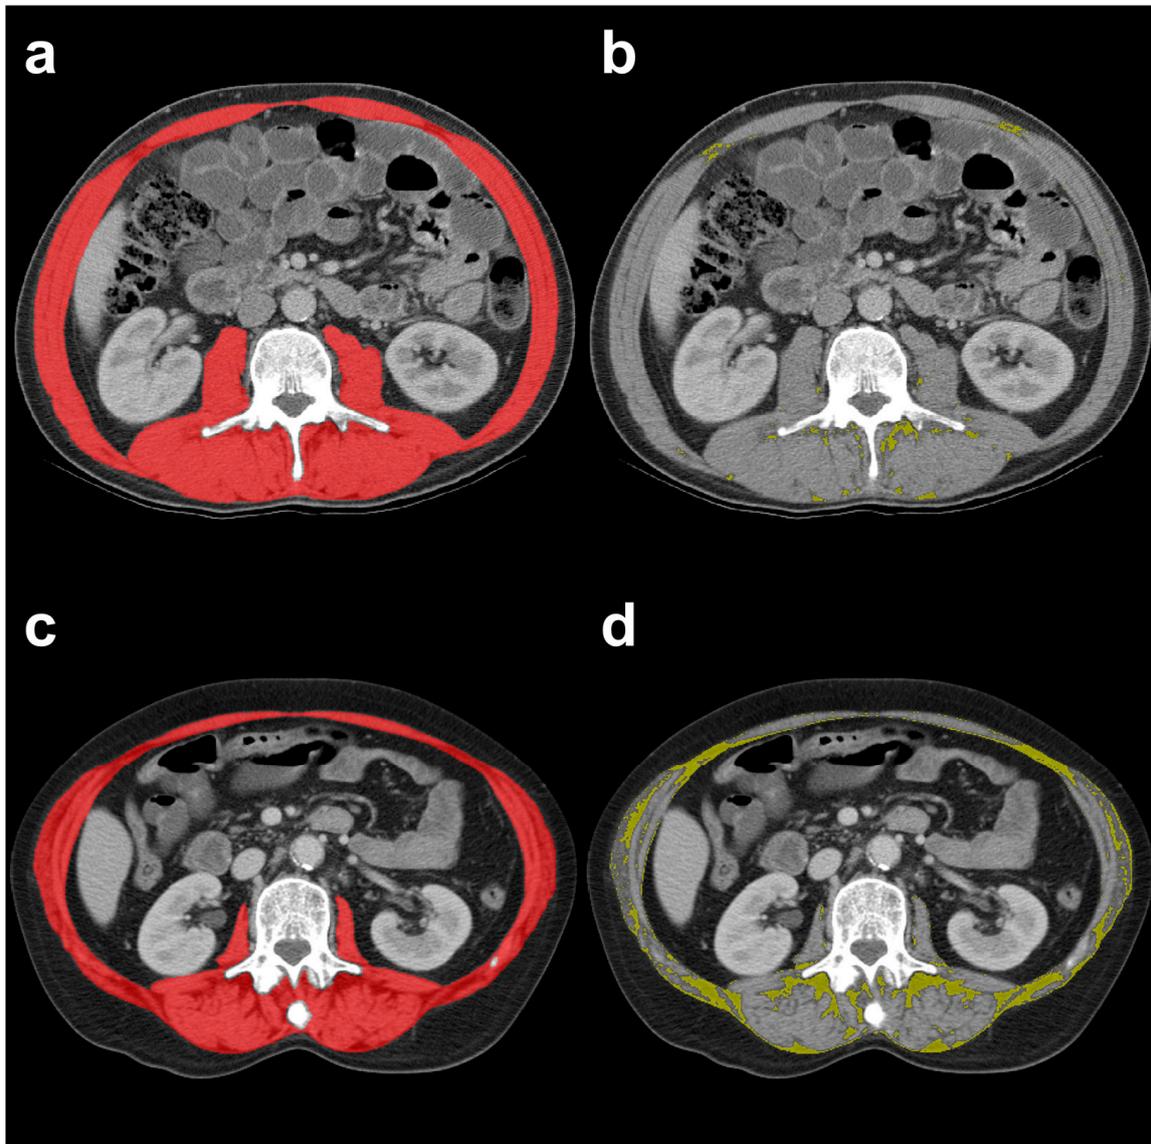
Representative examples of CT images at L3 level showing segmentation of the SMA ((a,c), color-coded in red) with secondary derivation of the IMAT area ((b,d), color-coded in yellow) in two HNC patients who underwent total laryngectomy with favorable (top row) and unfavorable (bottom row) postoperative clinical outcomes.
